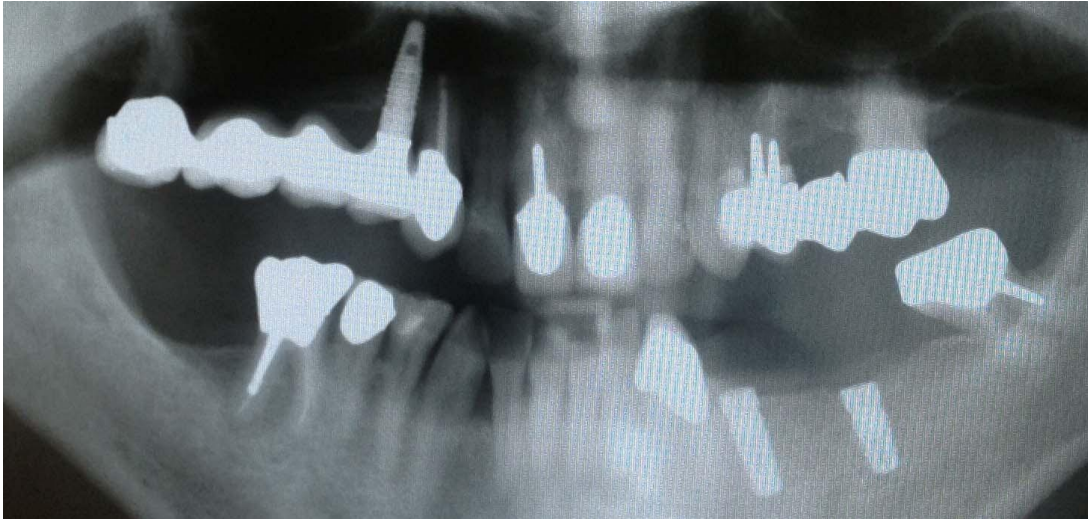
Panoramic x-ray incidence obtained from the upper and lower dental arches of the deceased (*antemortem*) made in 2003.
